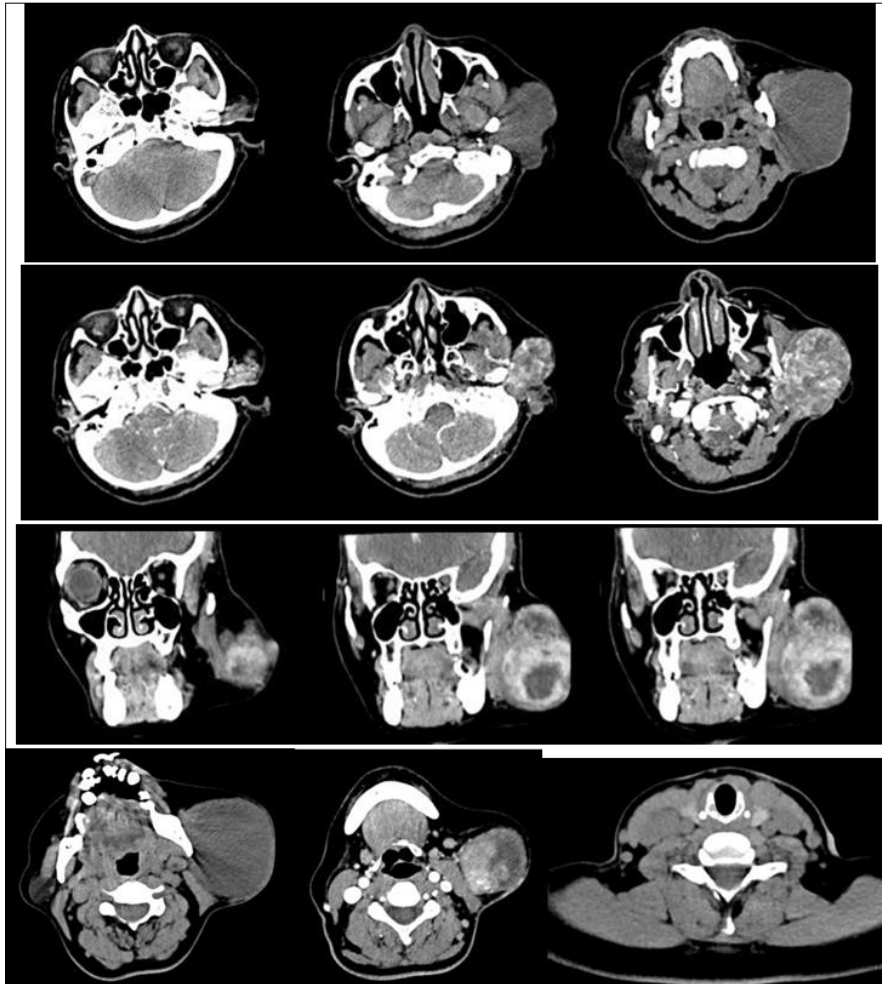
Axial, coronal, and sagittal slices of the contrast-enhanced midface CT scan show a tumor mass and bilateral lymph node enlargement
